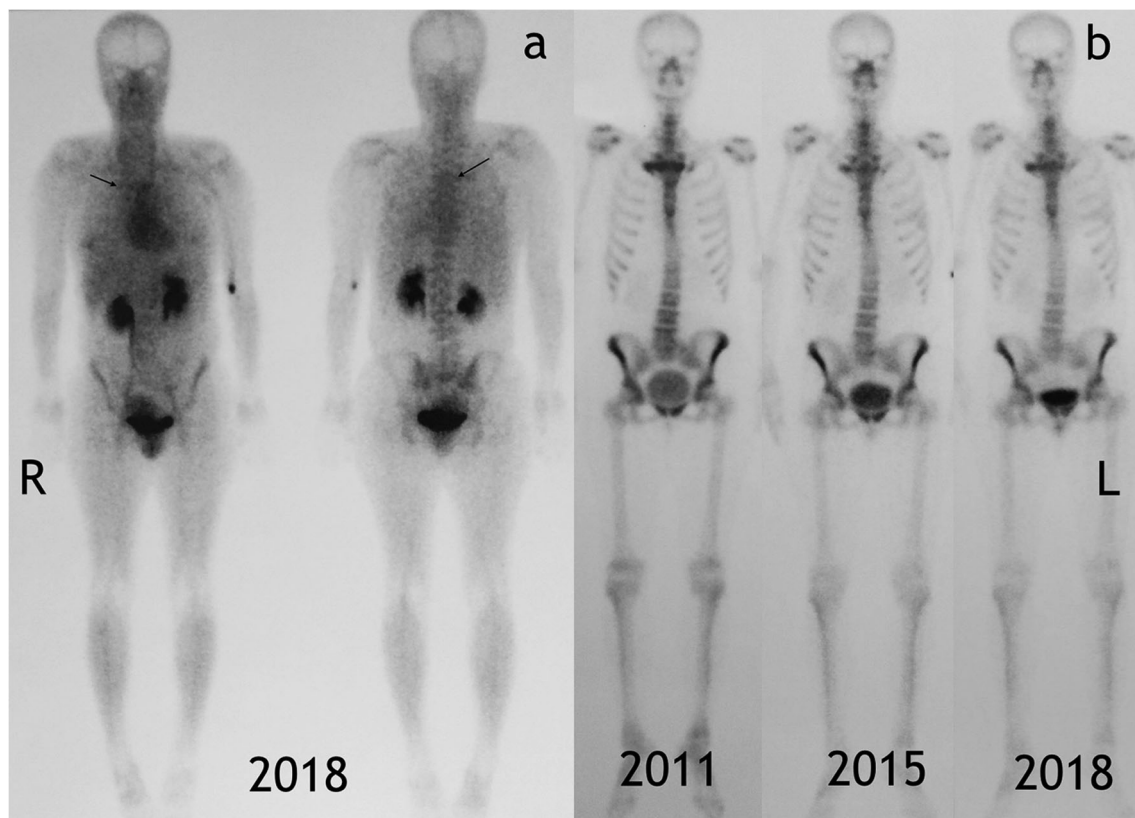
Sequential bone scintigraphy: Images obtained 5 min after intravenous injection of technetium-99m demonstrates slightly increased uptake (arrow) at the sternocostal joint of the first rib on the right, anterior and posterior views (arrows) (a); 2 h after injection there is increased
